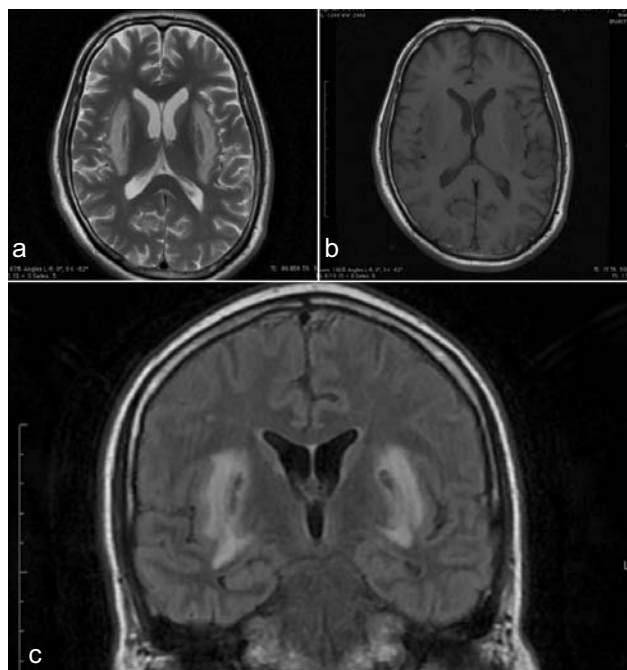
Shows Hemorrhagic necrosis of putamen bilaterally associated with surrounding edema. (a) T2w axial image shows hyper intense signals in bilateral basal ganglia representing edematous changes. (b) T1w axial image shows iso to hyper intense signals in basal ganglia. (c) Coronal FLAIR image shows hyper intense signals in bilateral basal ganglia representing edematous changes.
